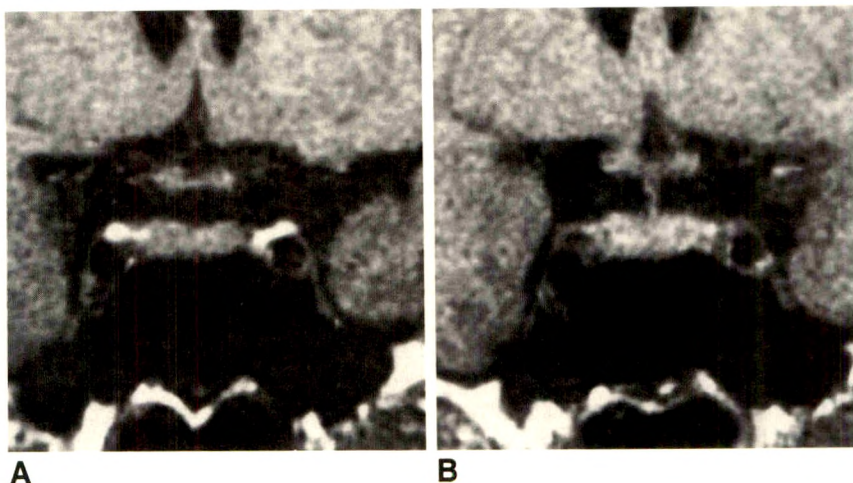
A and B, 41-year-old man with Cushing disease. T1-weighted coronal images, 600/20. Normal anterior lobe. Stalk is midline. Total hypophysectomy was performed after negative exploration. At final pathology, only normal pituitary gland was identified. (Left half = true negative; right half = true negative.)
